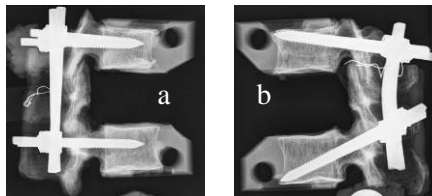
Radiographs of T-B (a) and Bridge (b) constructs. (levels T11-L1)
